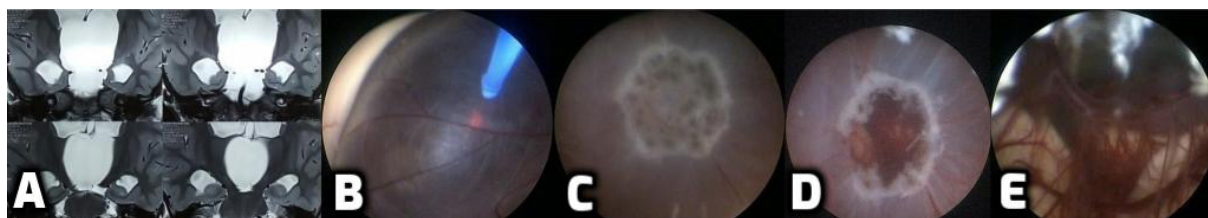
A: MRI T2W coronal section of giant suprasellar arachnoid cyst; B: coagulation of cyst wall by utilizing thulium LASER endoscopically; C: cyst wall after application of the LASER; D: perforated cyst wall; E: intracystic visualization after ventriculocystostomy
